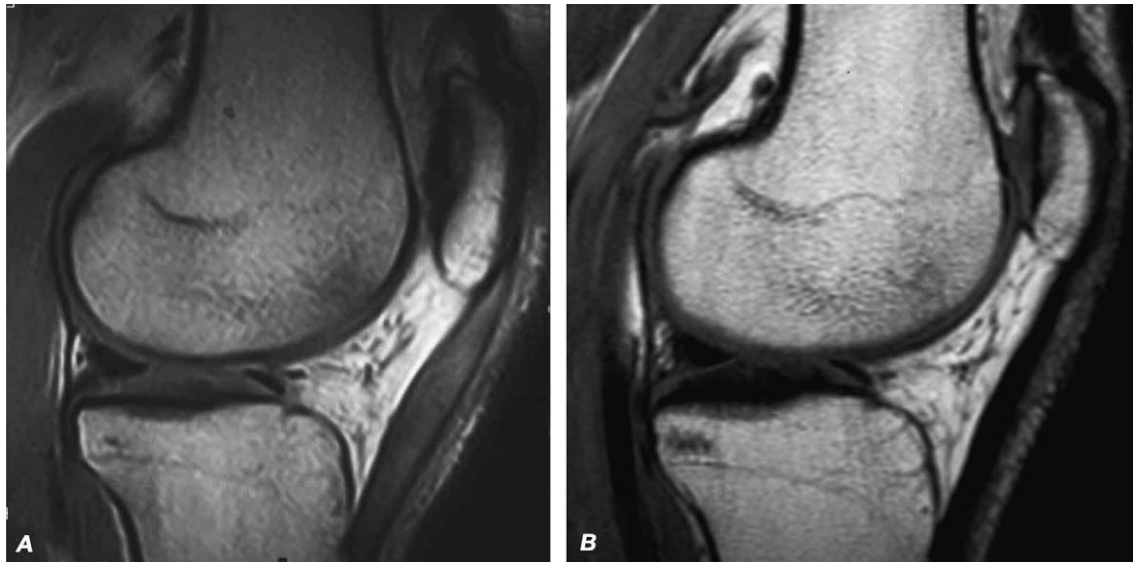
Magnetic resonance imaging shows the patellar tendon (A) before the treatment and (B) at 6 months follow-up after PRP injections, demonstrating improved tendon structure.
